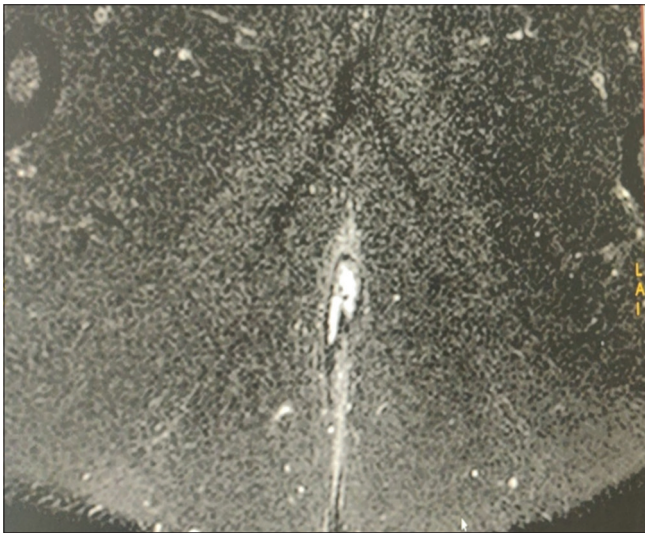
Case of intersphincteric fistula (magnetic resonance imaging Grade I) – axial T2 fat-saturated image showing internal opening on posterior aspect of anal canal
